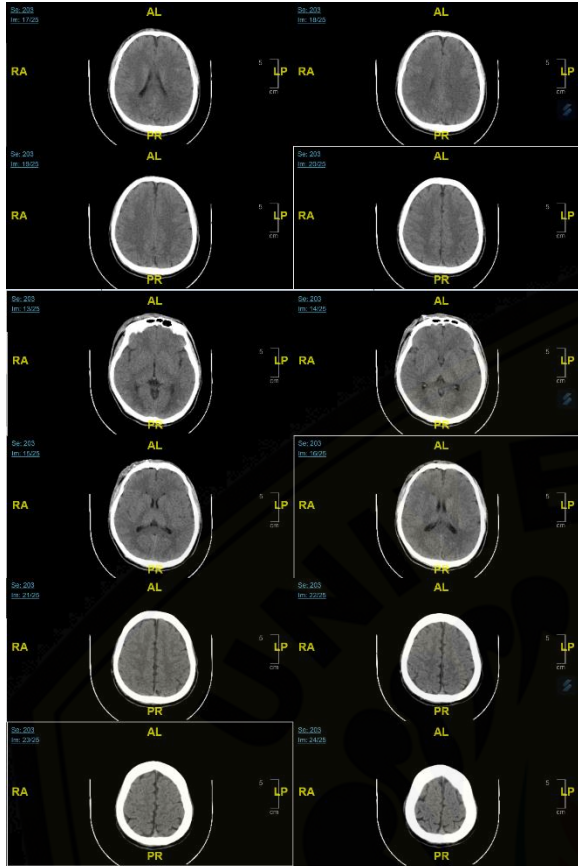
CT scan imaging, brain window
